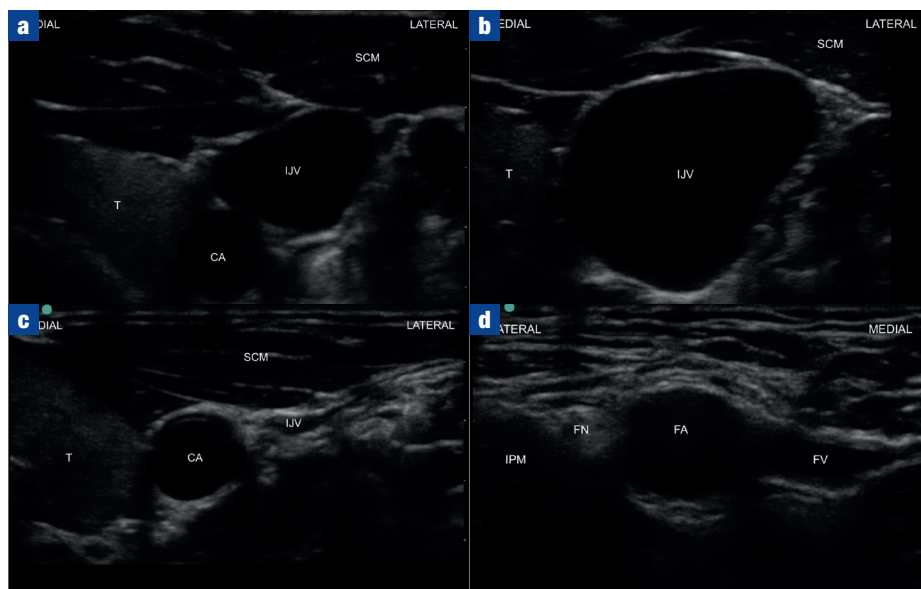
Ultrasound image in a short axis/transverse view of the right internal jugular vein (a) with no compression, (b) head down tilt and (c) compression and (d) of the left femoral vein, showing the anatomical relations of nearby structures and the effect of simple manoeuvres on the cross-sectional lumen of the vein. CA = carotid artery; FA = femoral artery; FN = femoral nerve; FV = femoral vein; IPM = iliopsoas muscle; SCM = sternocleidomastoid muscle; T = thyroid gland.
